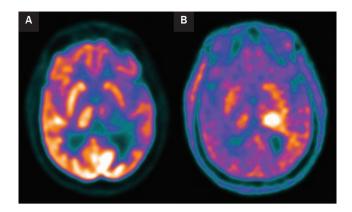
Differences in uptake of ¹⁸F-FDG and ¹⁸F-FET in primary brain tumor
